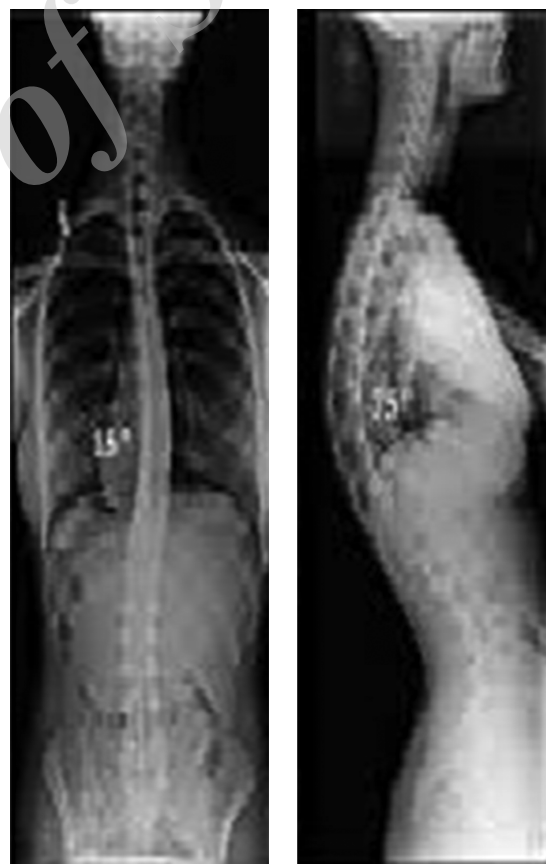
X-ray of a 15-year-old male with SK and Thoracic kyphosis up to 75 degrees, needing surgery
